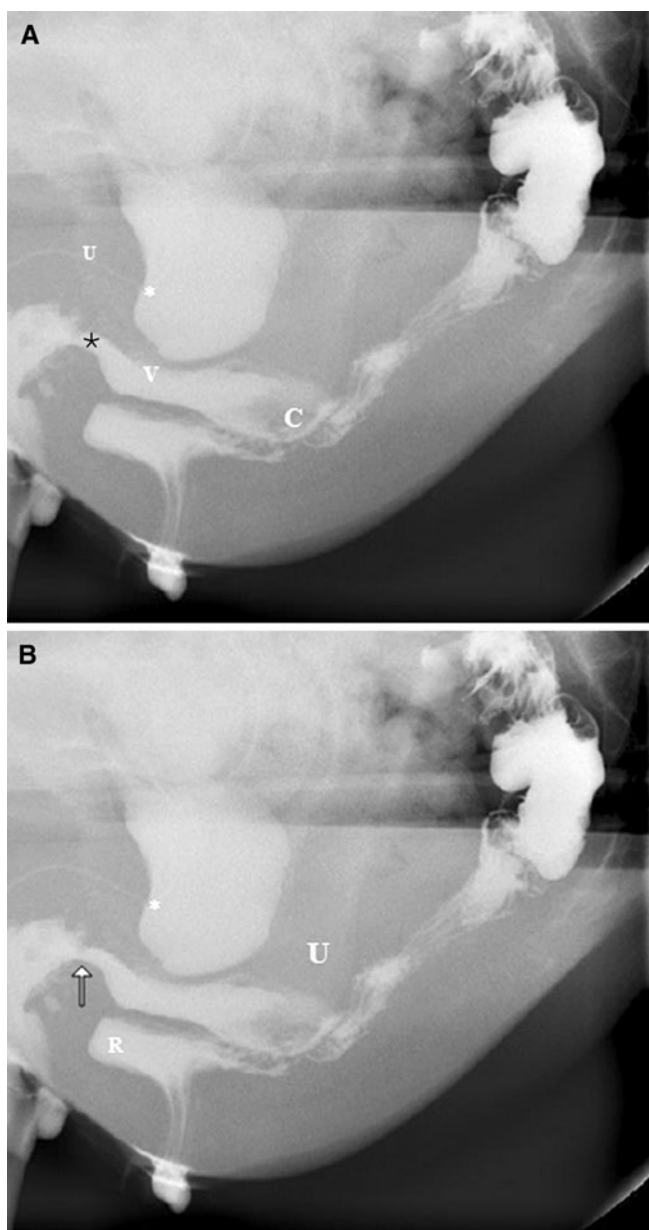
Diagnosis of intra-vaginal enterocele. A 58-year-old patient referred for DCP because of excessive straining at defecation and sensation of incomplete emptying and urinary incontinence. A Lateral strain radiograph obtained following the evacuation phase shows a Type C enterocele, Stage 2 cystocele and internal prolapse (*arrowhead*). \*PH. B Lateral strain radiograph obtained following suction of urinary bladder through 8F catheter and additional evacuation in the toilet shows an intra-vaginal enterocele (E) not shown in (A) because of a filled urinary bladder.
